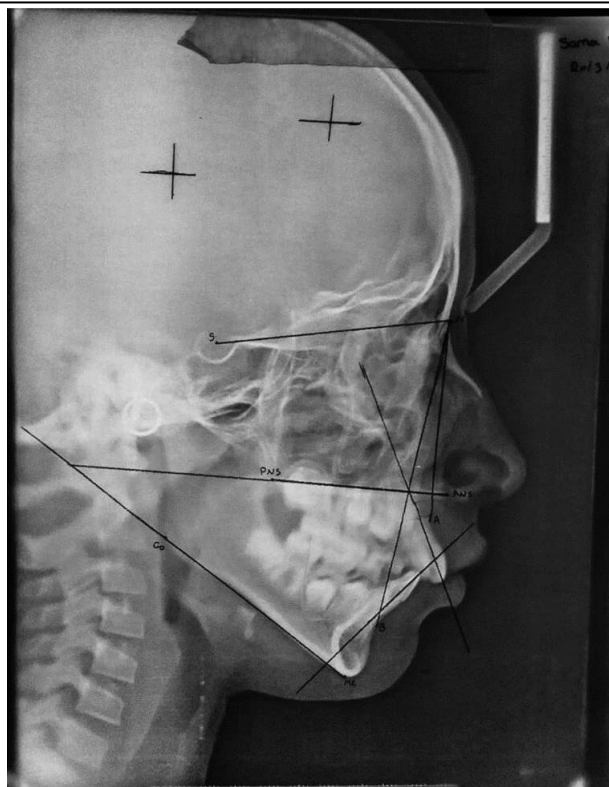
Photograph showing a cephalometric x-ray on the viewer traced by the manual method.
